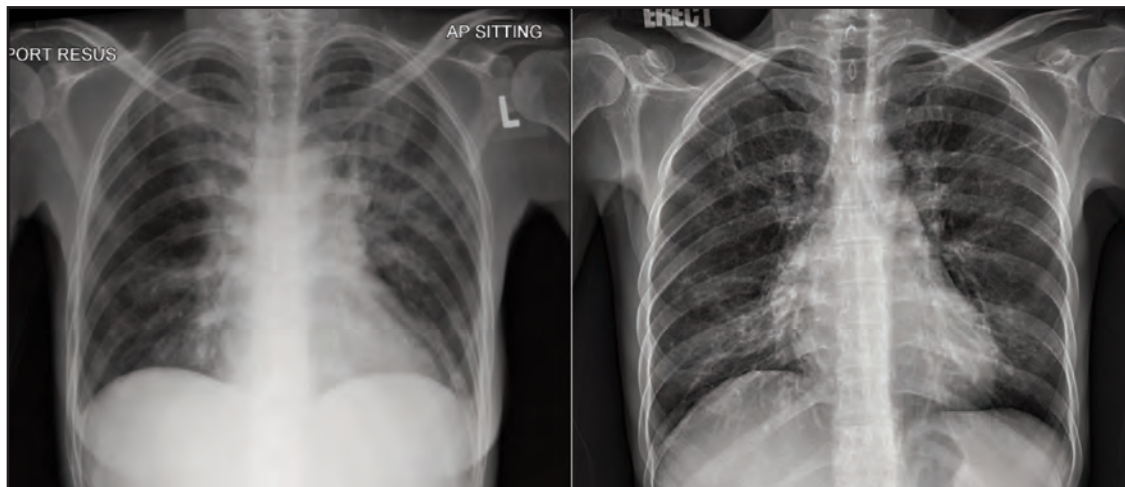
Left - Chest radiograph upon arrival at the emergency department with pneumonia changes seen over the bilateral upper lobe; Right - Chest radiograph after two courses of antibiotics and one course of IVIG showing resolution of pneumonia
